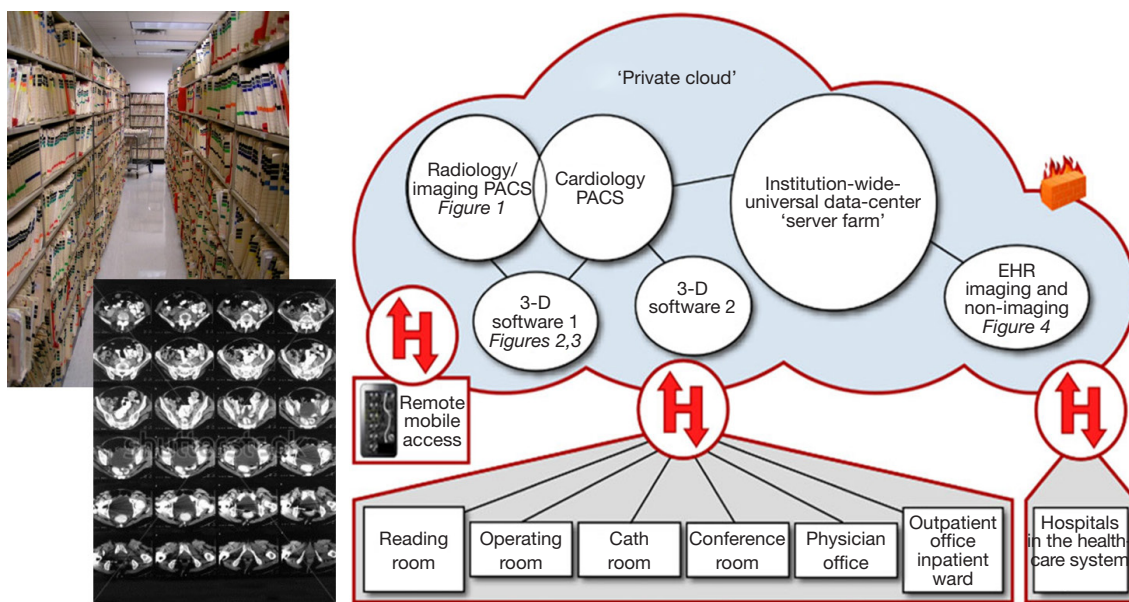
This figure shows storage of paper medical records and a printed CT ‘film’ in contrast to digital data storage in ‘private medical data clouds’. CT, computed tomography; PACS, picture archiving and communication system. EHR, electronic health record.
